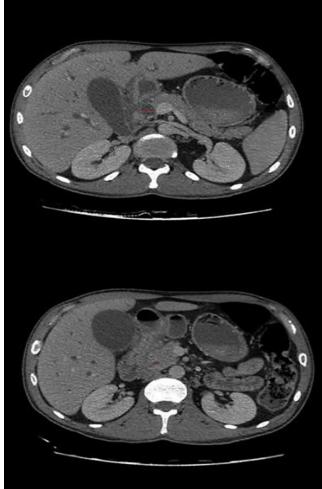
Axial CT scan showing the dilation of the main bile duct upstream of the tumor
